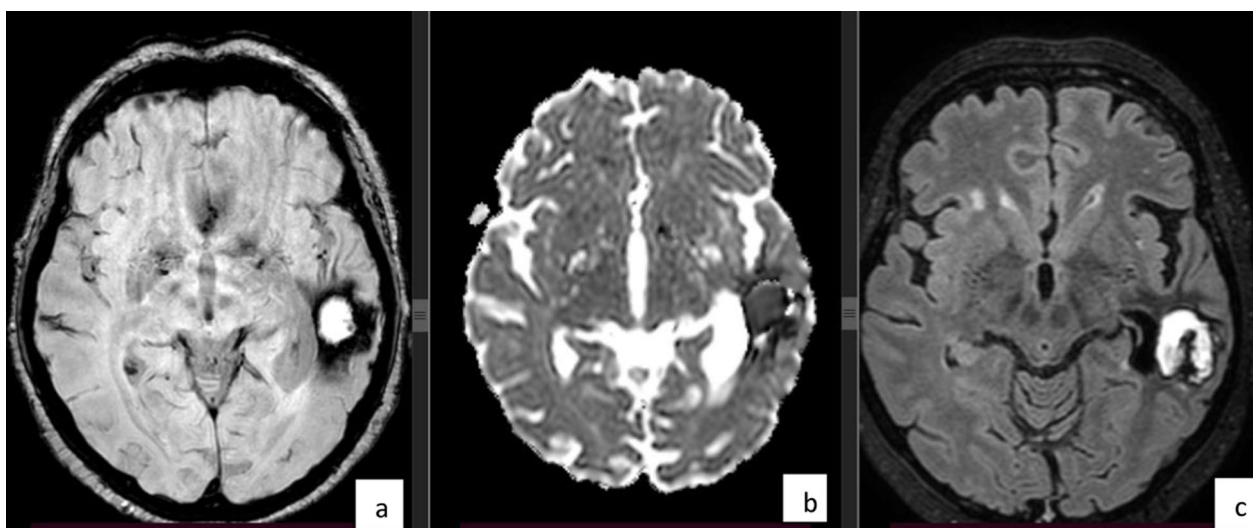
a Axial SWI suggestive of left temporal HS with the signs of blood fragmentation. b Axial ADC maps show reduced values consistent with late subacute phase. c FLAIR shows a hyperintensive focus in the left temporal subcortical area with perifocal edema
